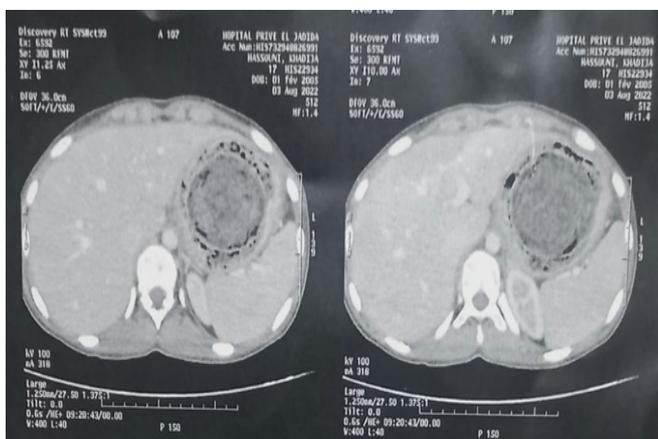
Abdominal CT in axial section showing a gastric trichobezoar
